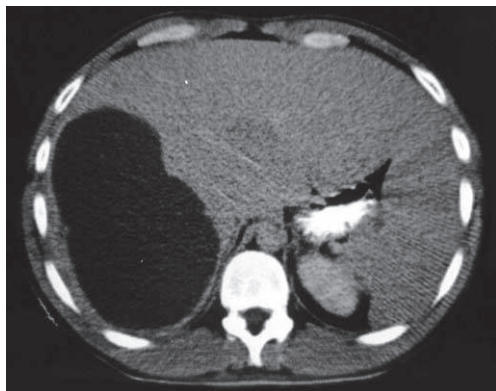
Abdominal computed tomography scan showing a large hypodense mass in the right hepatic lobe.
